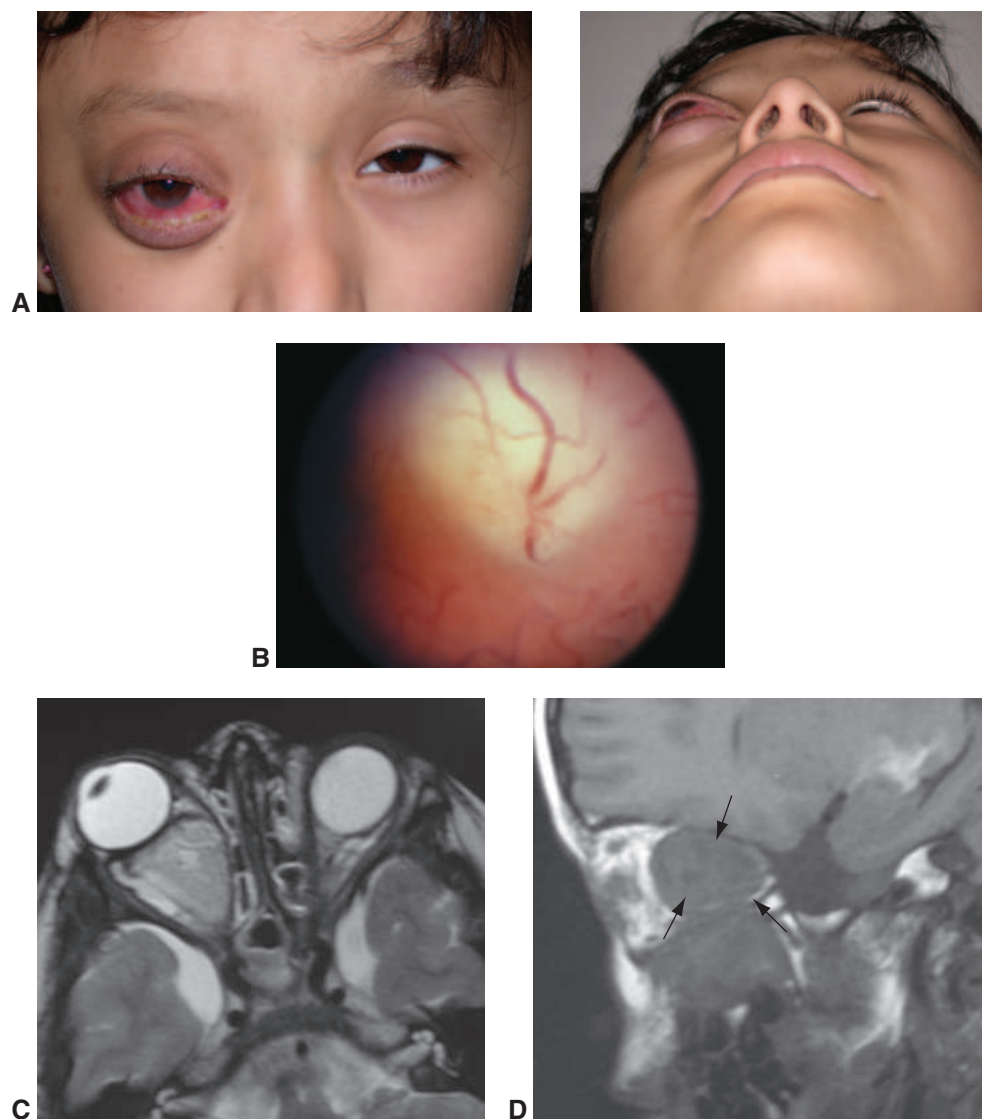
Optic nerve glioma. A, Right optic nerve glioma. The patient has severe proptosis with exposure and light perception vision. B, Funduscopy view. Note swollen optic nerve head with obscured margins. C, T2-weighted axial MRI shows glioma extending into the optic canal. D, Sagittal MRI shows a heterogeneous mass (arrows) in the apex of the orbit. (Parts A, C, and D courtesy of Raymond Douglas, MD; part B courtesy of Roger A. Dailey, MD.)
